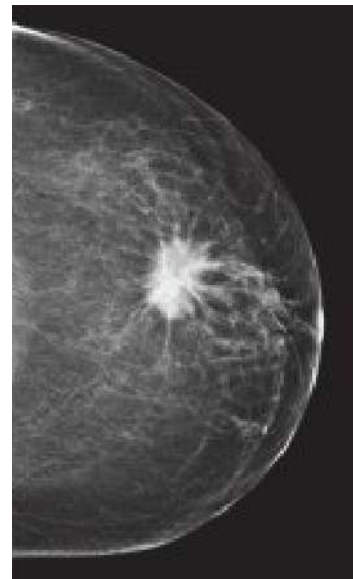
X-ray of the breast (mammography) of a 23-year-old woman. [G198]
